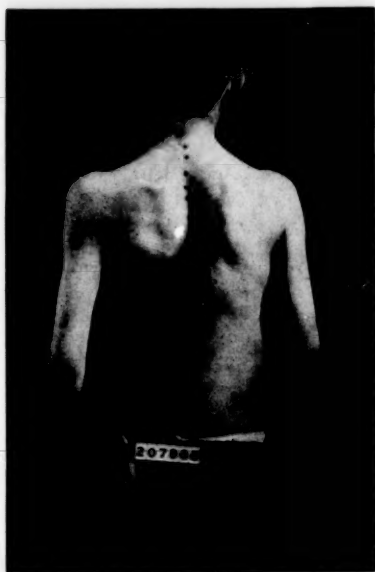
(See x-ray tracing, Fig. 26.)
